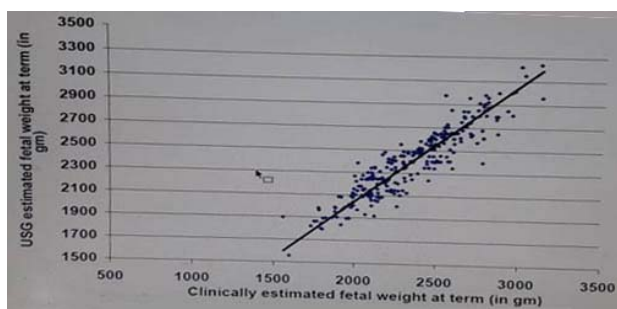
Correlation between clinically estimated Fetal Weight and Ultrasound Assessed Fetal Weight at term
